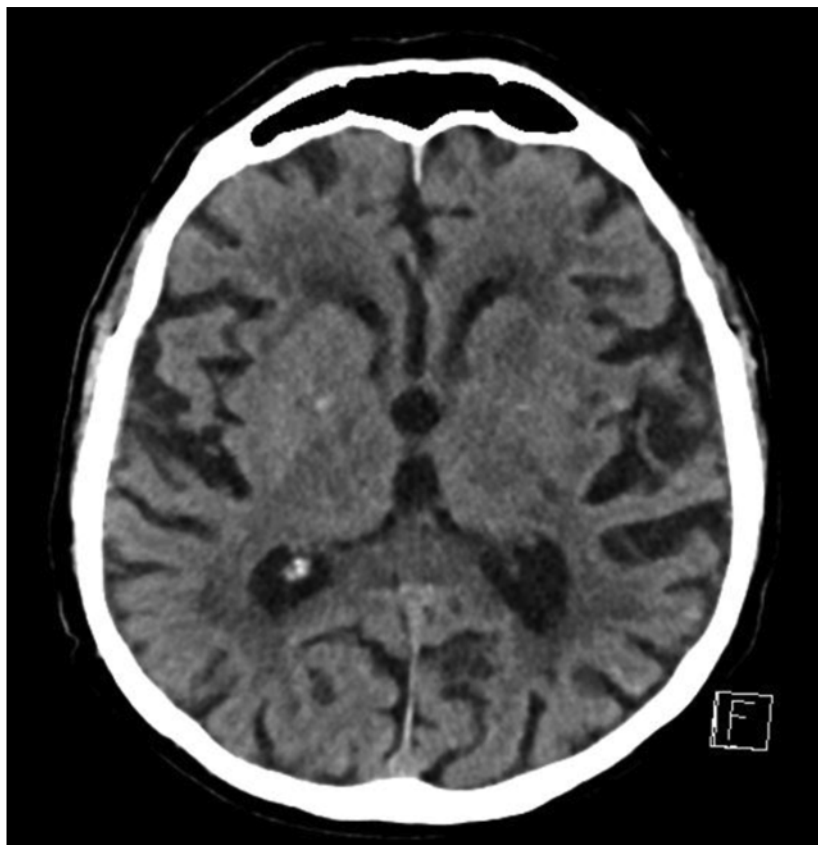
Follow up CT scan
